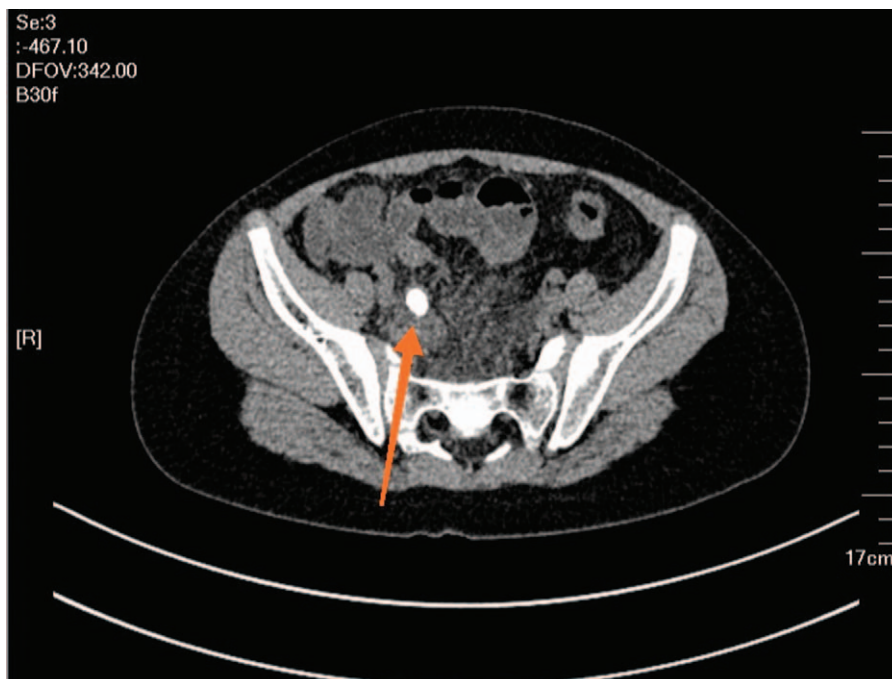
Abdominal computed tomography demonstrating appendicolith up to 2 cm.
